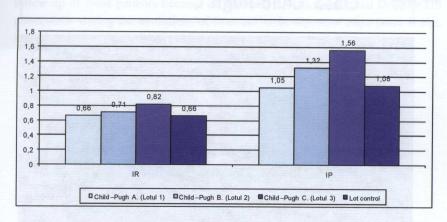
Renal Doppler US parameters in patients with liver cirrhosis according to Child-Pugh classification.
